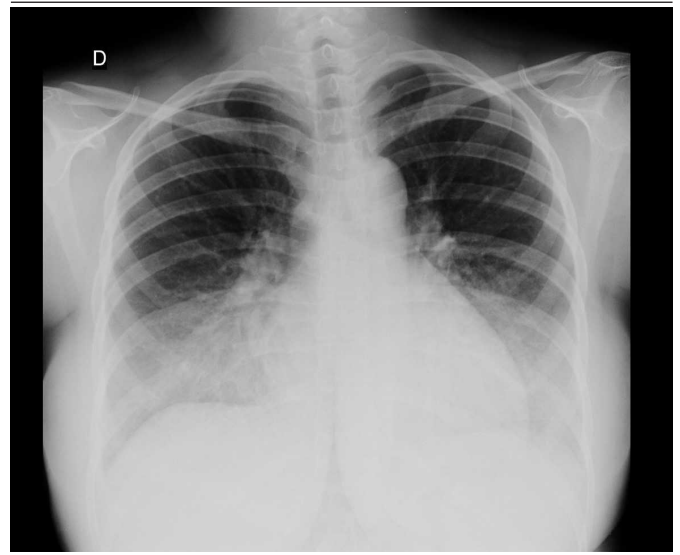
Posteroanterior chest view radiograph
